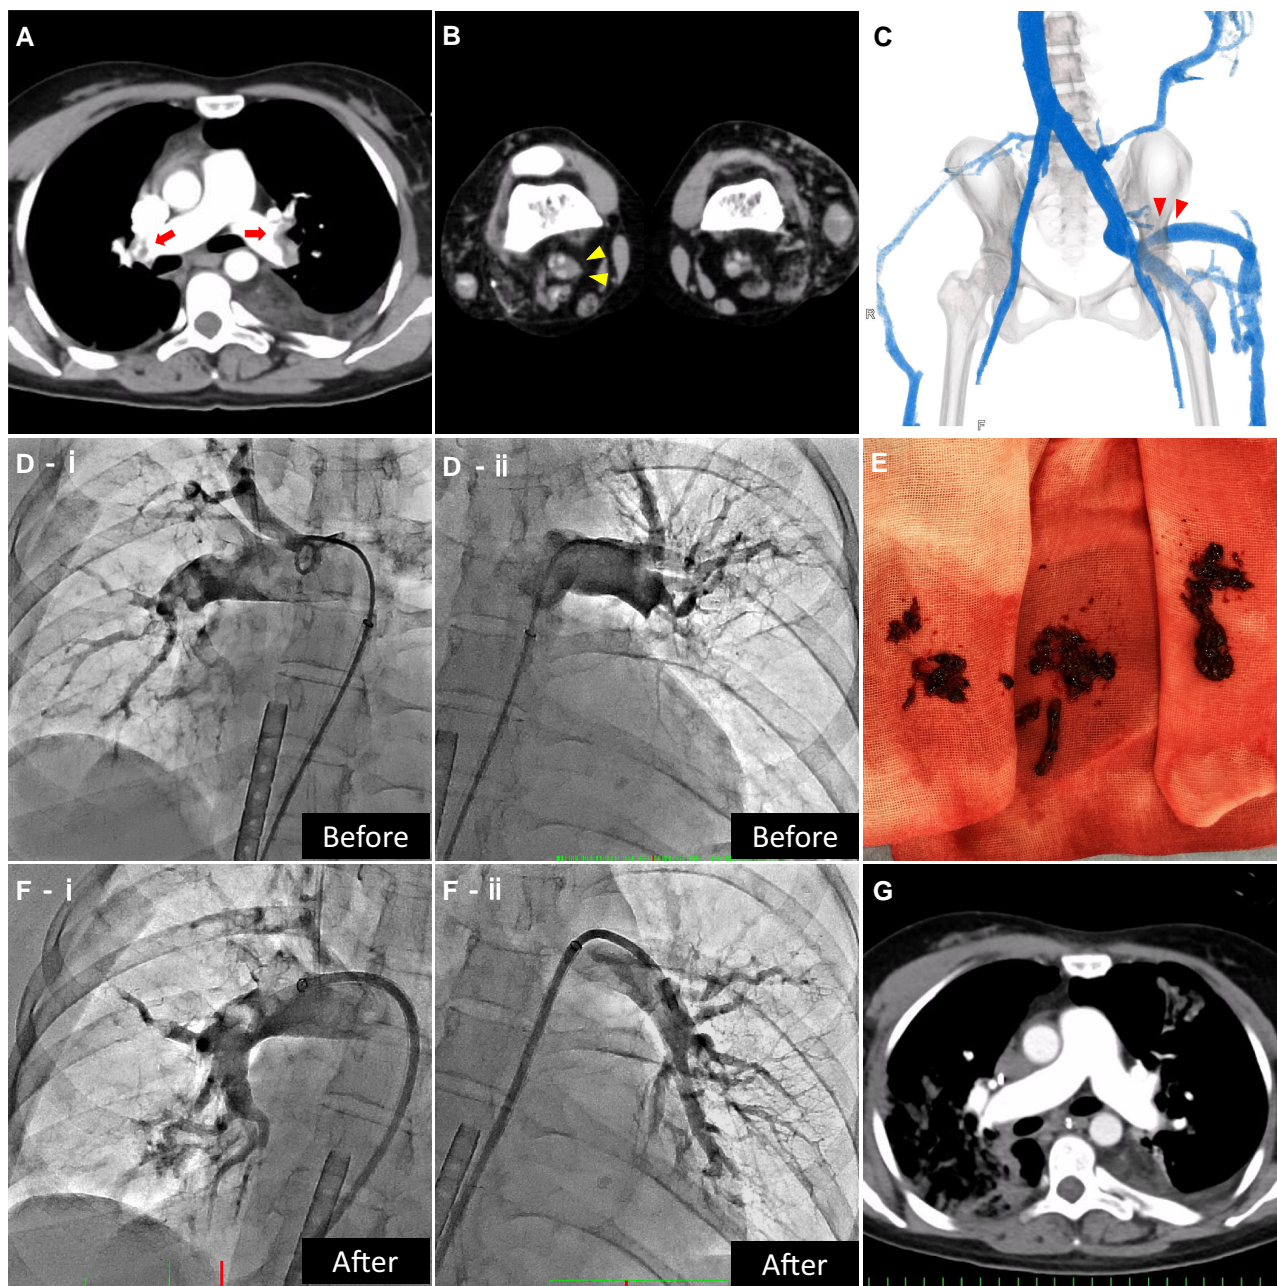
(A and B) Contrast-enhanced computed tomography scan on admission performed according to our local protocol, with imaging done from the thorax to the lower extremities, showing bilateral pulmonary embolism (red arrows) and a deep vein thrombus from the right great saphenous vein to the popliteal vein (yellow triangles). (C) Three-dimensional-computed tomography angiogram showing venous malformations, including a dilated left iliac vein and persistent sciatic vein branching from the left iliac vein (red triangles). (D) Pulmonary angiography images show an extensive thrombus in the main trunk of the pulmonary artery. (E) A guiding catheter successfully aspirated a large amount of thrombus, (F) which improved blood flow. (G) A repeat computed tomography scan shows the disappearance of the extensive thrombus.
